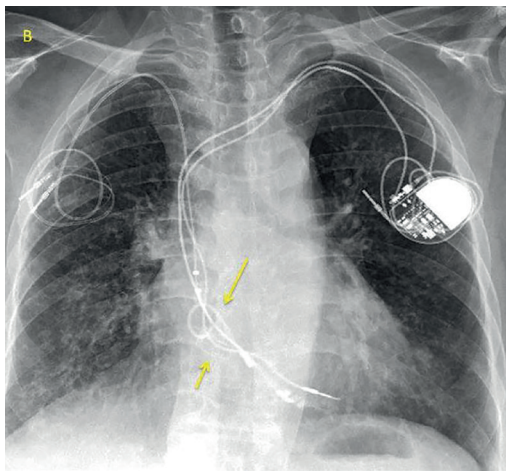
Chest radiography after hospital discharge showing multiple leads.
